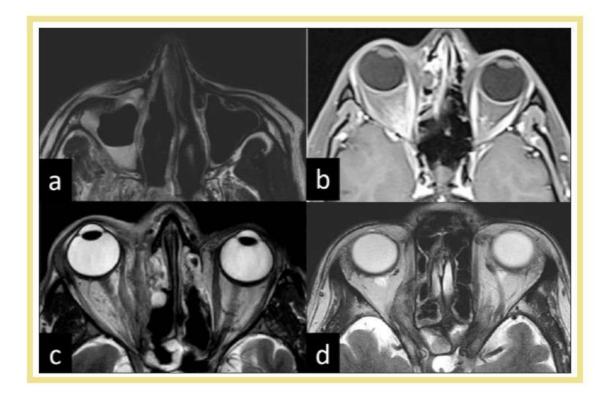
MRI showing various stages of ROCM. Fig 1a: Stage 3a - Axial T2 weighted MR showing involvement of the right nasolacrimal duct (red arrow), extending into the medial orbit; Fig 1b: Stage 3b - Axial contrastenhanced MRI (T1) of the orbit, par nasal sinuses, and brain showing involvement of the medial orbit and abnormal intensity of the orbital fat in the posterior orbit along with involvement of the right ethnocide sinus; Fig 1c: Stage 3c - Axial MRI (T2) showing right ethnocide sinus and diffuse orbital involvement extending to the orbital apex; Fig 1d: Stage 3d - Axial MRI (T2) of the orbit and par nasal sinuses showing bilateral orbital apical involvement, more extensive on the right side.(Courtesy - Sen et αP).
